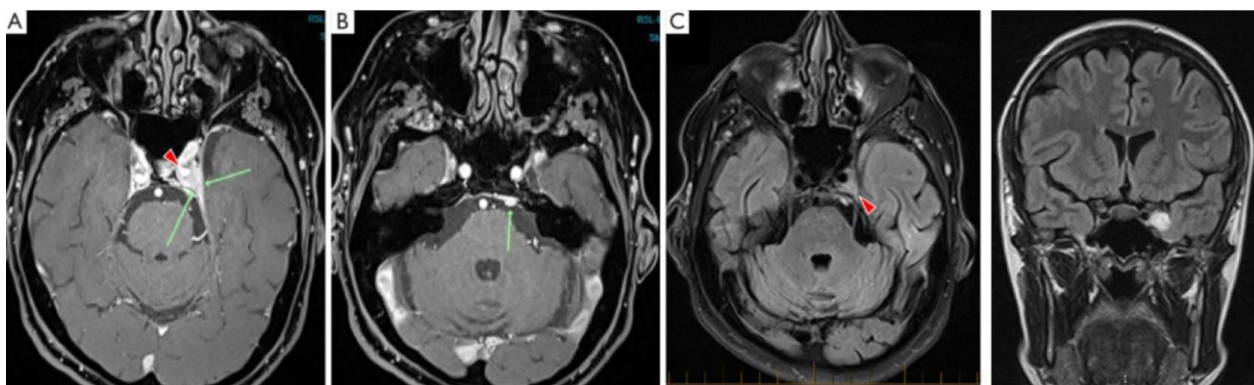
Axial and coronal MRI views demonstrating a right cavernous sinus meningioma (arrow).
